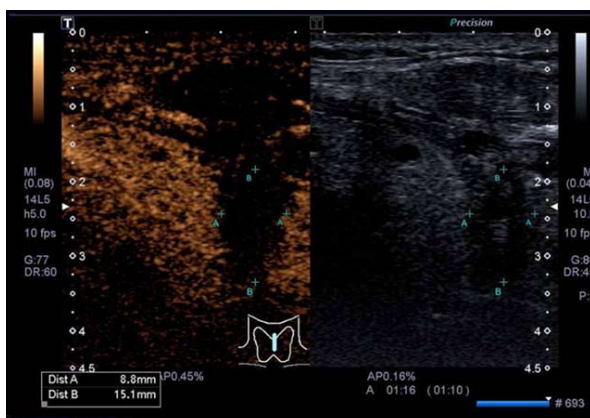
Two-dimensional and contrast-enhanced ultrasound images (no lesions intensified, completely ablated).
